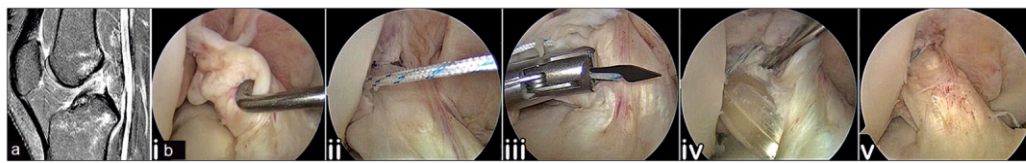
Remnant sparing anterior cruciate ligament (ACL) reconstruction. (a) MRI reveals a recent ACL femoral avulsion of Sherman Type II (b) arthroscopic technique involves (i) identifying the ACL femoral avulsion and creating tunnels at the anatomical insertion sites, (ii) inserting a curved suture anchor anterior to the ACL femoral tunnel within the footprint of the ACL, (iii) passing one limb of the suture in mattress configuration through the ACL remnant, (iv) ACL graft passage while retracting the ACL stump, (v) a knot is now applied to the sutures so that the remnant envelopes the ACL graft and is fixed to the femoral insertion footprint.
